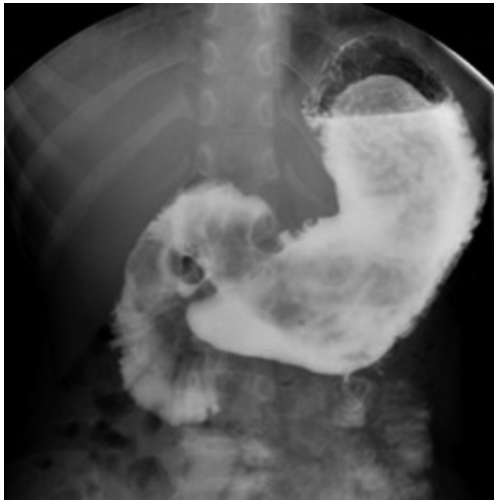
Gastrointestinal tract radiography imaging. Multiple filling defects in the gastric body and sinus region.
